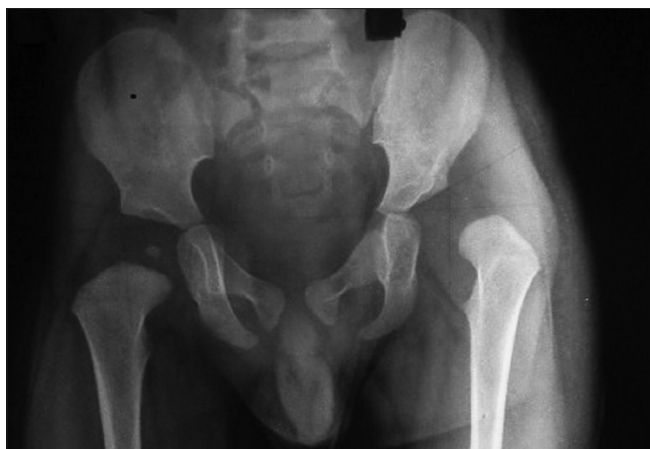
X-ray anteroposterior view of pelvis showing both hips in a 16-month-old infant showing unilateral developmental dysplasia of the hip on the left side with absence of ossific nucleus at the time of open reduction
